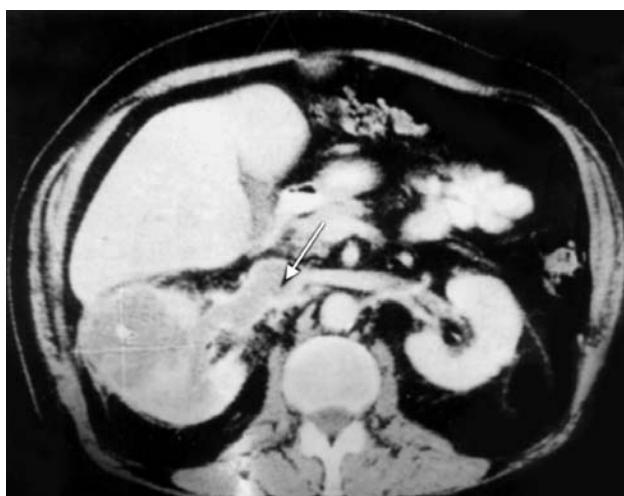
CT scan showing renal cell carcinoma (←)
